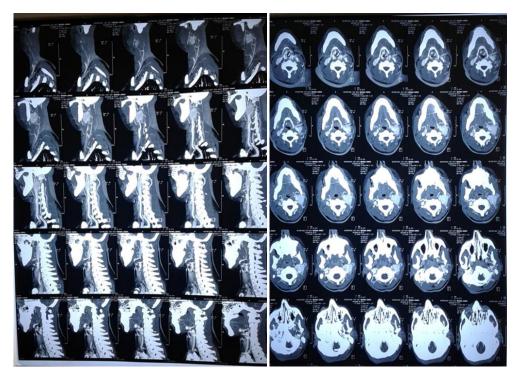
Head and neck CT scan (axial and sagittal plan)
